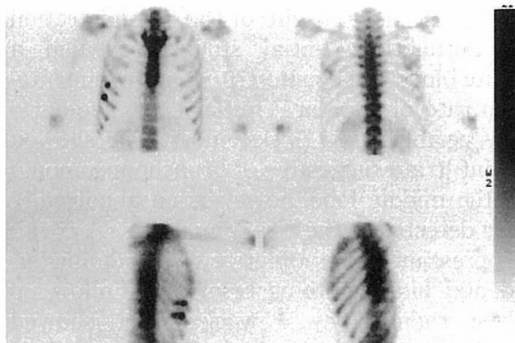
Bone scintigraphy showing an abnormal accumulation only at the right the 5th and 6th rib. Laterla views revealed that the lesions were located in the axillary line. Abnormal accumulations were noted in the adjacent above and below ribs.
